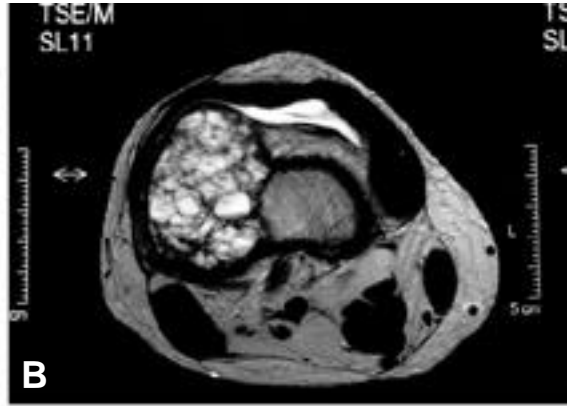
T2W1 MRI shows a large cystic mass with multiple septa and air-fluid levels.
